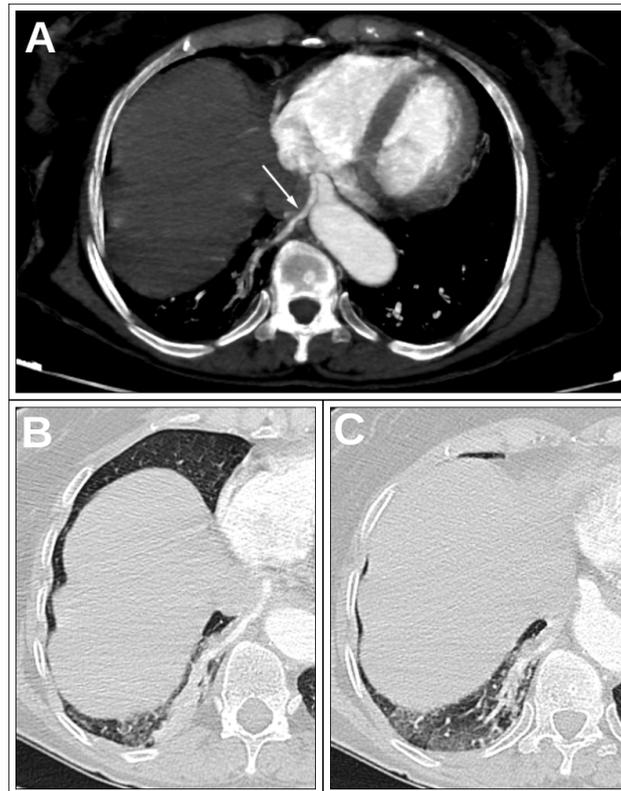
Axial slices from a thoracic CT-Aortogram (CTA) showing a thoracic aortic branch (Arrow in panel A) heading to a right mediobasal lung consolidation (panels B and C).
